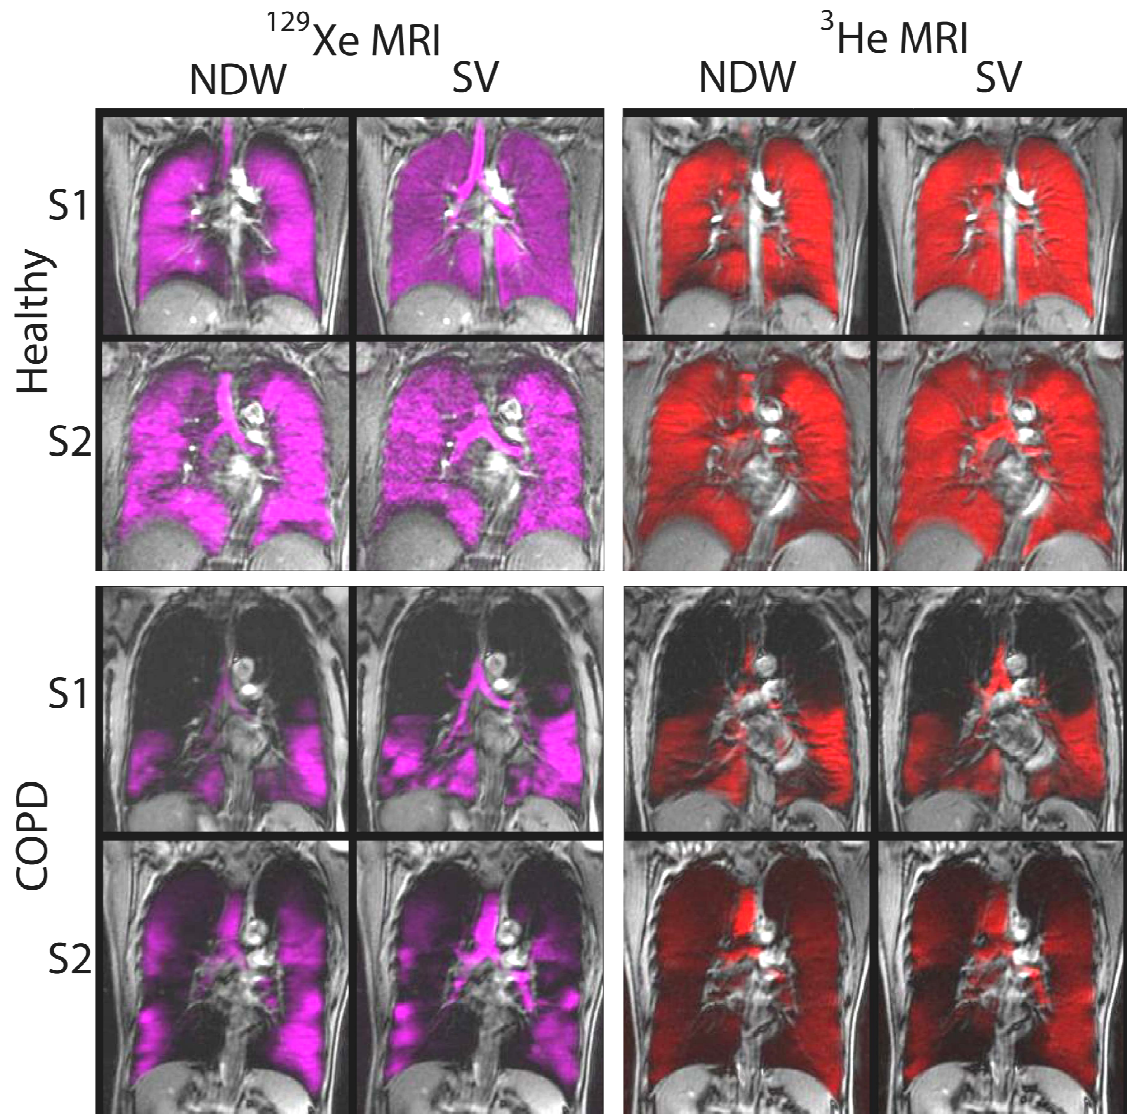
Non Diffusion Weighted (NDW) and static ventilation (SV) center slice images for ^{129}Xe and ^3He MRI for healthy volunteers and COPD subjects
